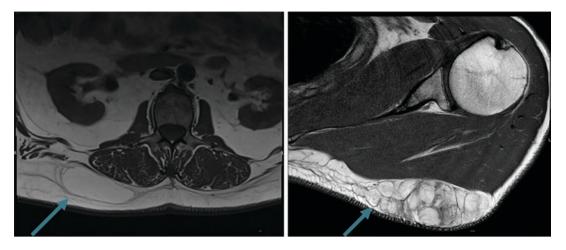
Appearance of lipomatous lesions on MRI. (Left): Homogeneous appearance likely to be benign. (Right): Heterogeneous appearance suspicious of malignancy
